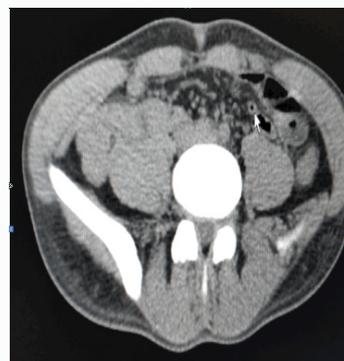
CT Scan showing appendix left side shown by arrow.
